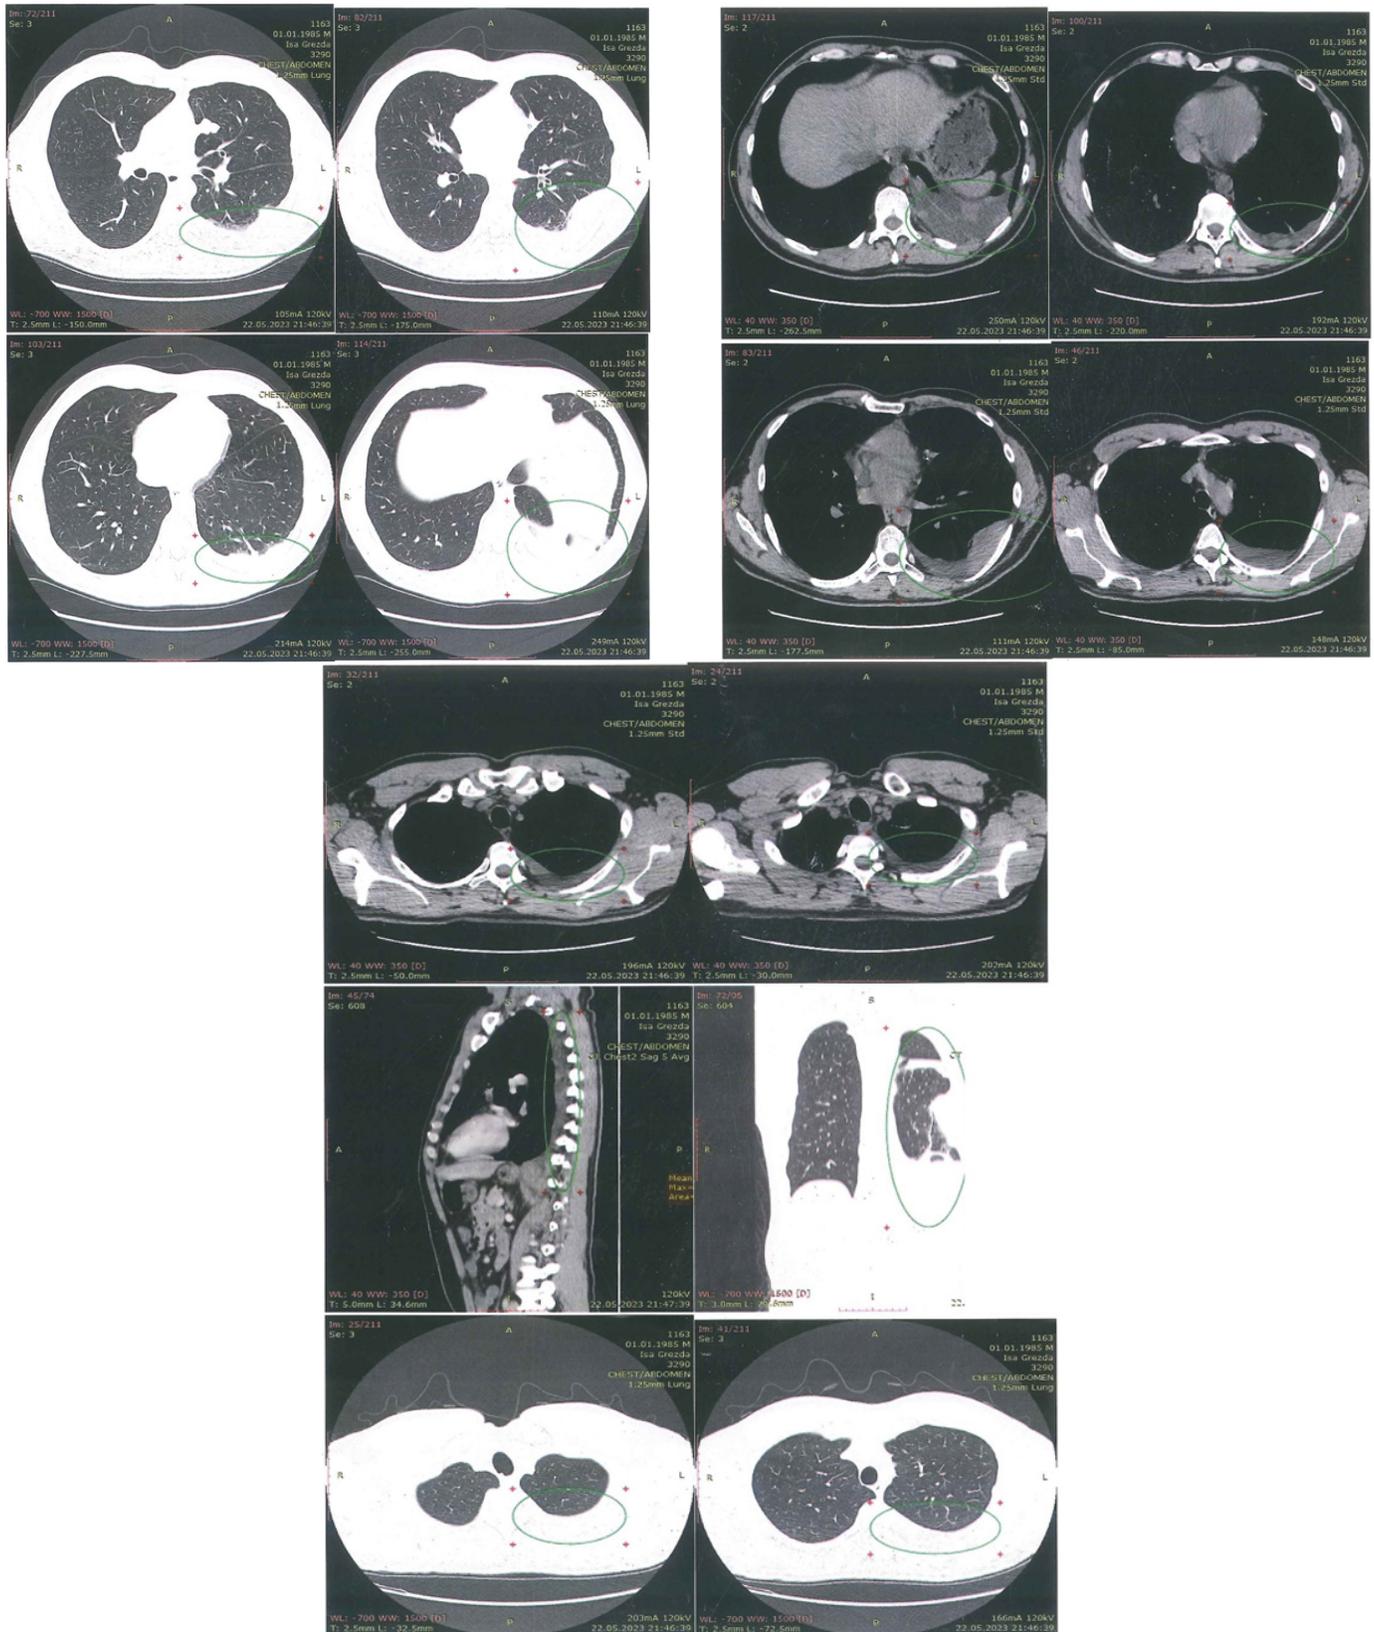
May 2023: Thorax CT after chemotherapy.
